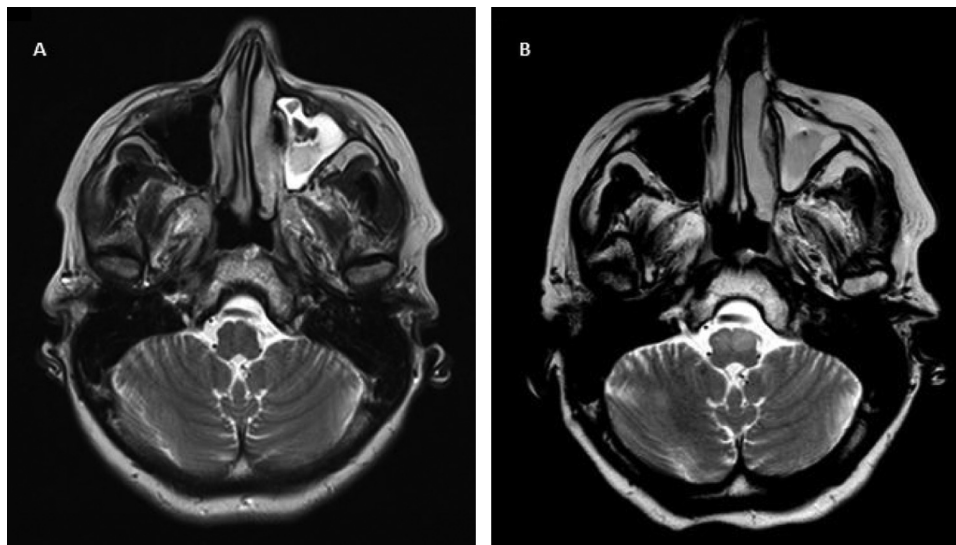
Patient 17: A. preoperative axial T2-weighted MR image showing normal bulbar olives. B. Postoperative last FUP T2-weighted brain MRI showing HOD with hyperintensity of both inferior olivary nuclei.
